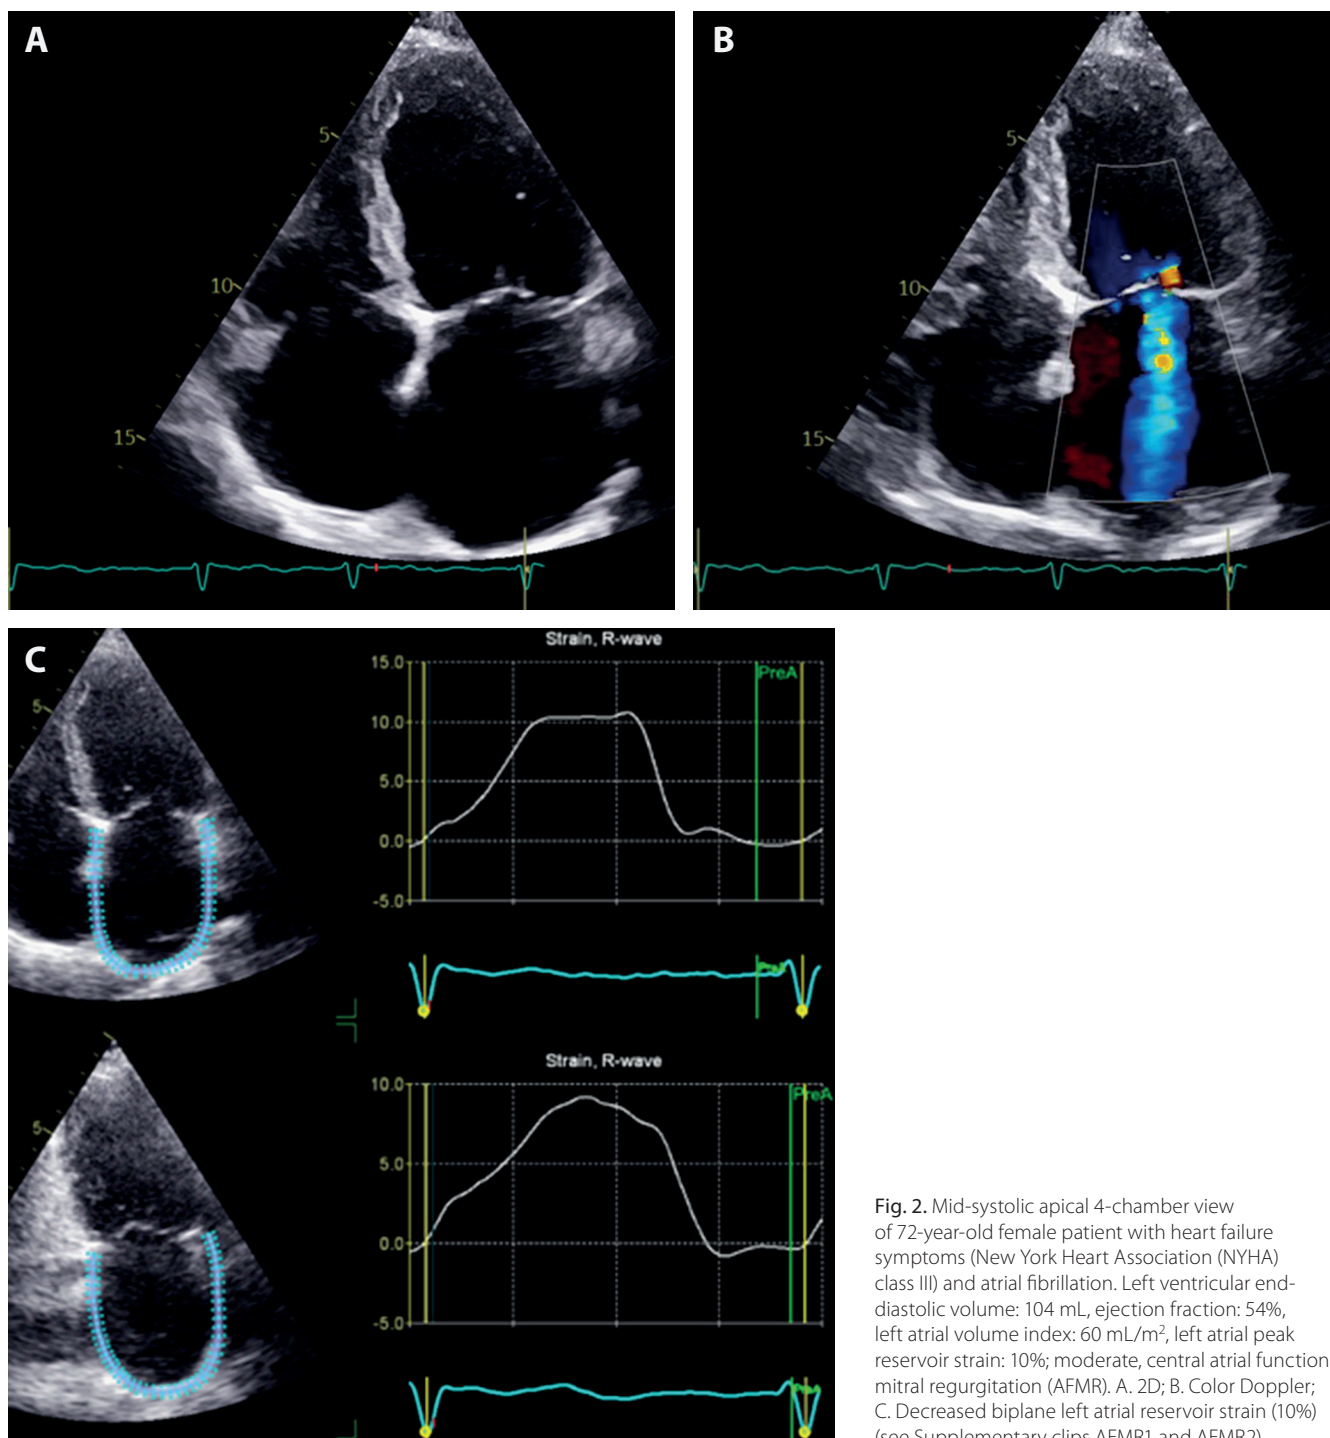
Mid-systolic apical 4-chamber view of 72-year-old female patient with heart failure symptoms (New York Heart Association (NYHA) class III) and atrial fibrillation. Left ventricular end-diastolic volume: 104 mL, ejection fraction: 54%, left atrial volume index: 60 mL/m², left atrial peak reservoir strain: 10%; moderate, central atrial functional mitral regurgitation (AFMR). A. 2D; B. Color Doppler; C. Decreased biplane left atrial reservoir strain (10%) (see Supplementary clips AFMR1 and AFMR2)
